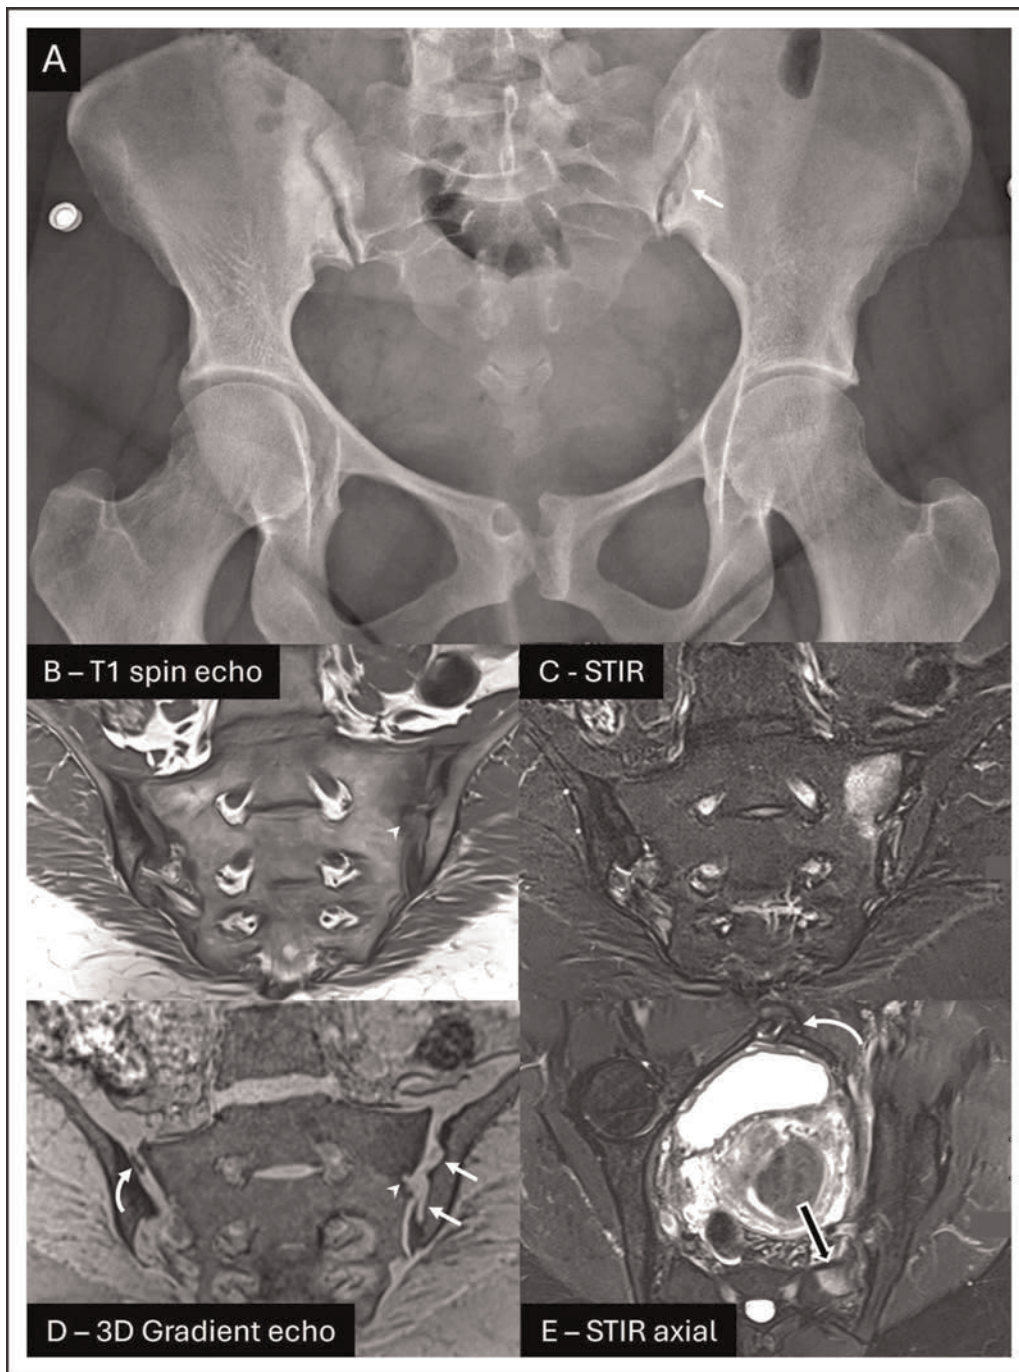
A 43-year-old woman with acute on chronic buttock pain was referred because of uncertain findings on pelvic radiography (a). The MRI scan confirmed bilateral osteitis condensans ilii (OCI) but a large area of BME and some irregularity of the left SU articular surface raised the possibility of coexistent axSpA. However, large defects in the left ilium relate to ligament insertions (straight arrows in a and d), and congenital asymmetry of the sacrum is present with a much smaller defect in the left sacrum (arrowheads in b and d) also related to a ligament insertion and not erosion. On the semiaxial STIR (e), the BME has the shape of a slice of pie with the apex of the lesion at the anterolateral corner of the left SU. The BME extends for an equal distance along the anterior nonarticular border of the sacrum (straight black arrow in e) and along the articular surface, and it is least intense at its apex due to the prominent sclerosis at this point. The shape and configuration of the BME lesion is typical for a mechanical cause. Osteitis pubis, also consistent with chronic strain, is much easier to detect on radiography (a) than it is to see on MRI (curved arrow in e) where the absence of active inflammation makes the distorted symphysis pubis hard to see. In clinical follow-up, the patient was HLA-B27-negative, acute-phase reactants were normal, there was a prior history of several term pregnancies, and the final diagnosis was osteitis condensans ilii with subacute stress reaction in the left SU exaggerated by anatomical asymmetry.
